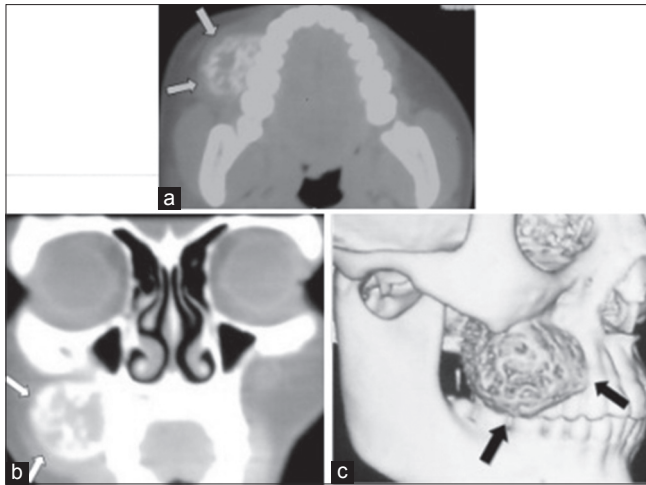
(a) Axial CT showing hyperdense radiopaque lesion, slightly dense at base than at periphery. (b) Coronal CT showing intact cortex and broad base of the lesion. (c) 3D-CT showing exophytic bony mass showing network of multiple intercoalescing radiating striae. 3D-CT = Three-dimensional computed tomography
